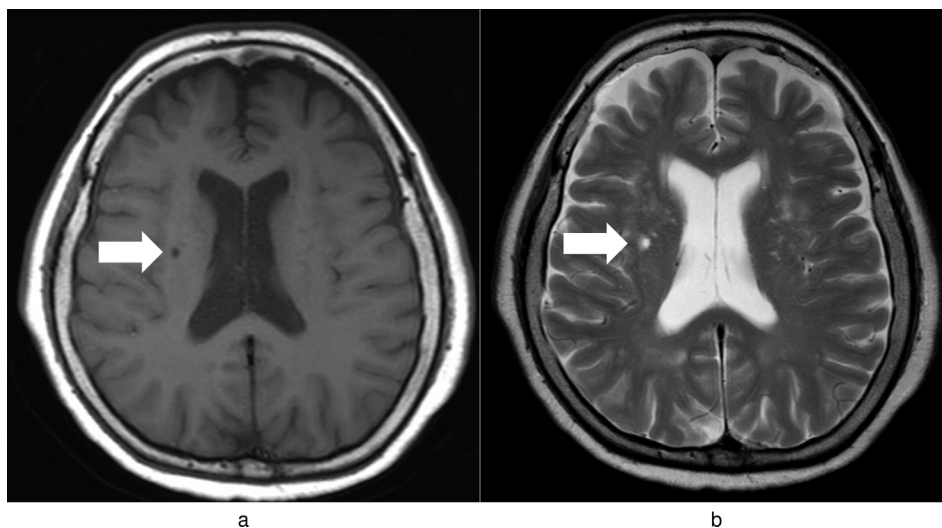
Example images of silent brain infarction on brain magnetic resonance imaging. A small (5 mm) silent brain infarct in the basal ganglia (arrow) is visible as a hypointense on T1-weighted image (a) and as a hyperintense on T2-weighted image (b).
